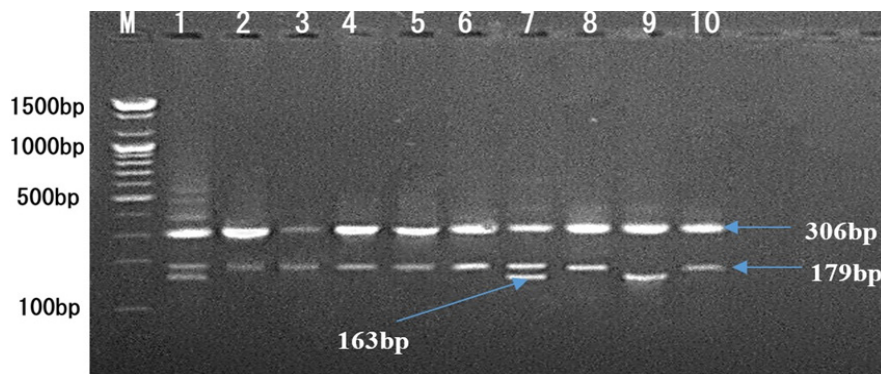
Representative Agarose Gel Electrophoresis of ARMS-PCR Products for the TGF-β (+869 C/T) Polymorphism. The analysis reveals three distinct genotypes based on the pattern of amplified DNA fragments. C common control band is visible at 306 and 179bp in all successfully amplified samples. The allele-specific primers produce (306, 179 and 163) bp band for the CT allele and 163 bp band for the T-allele.
